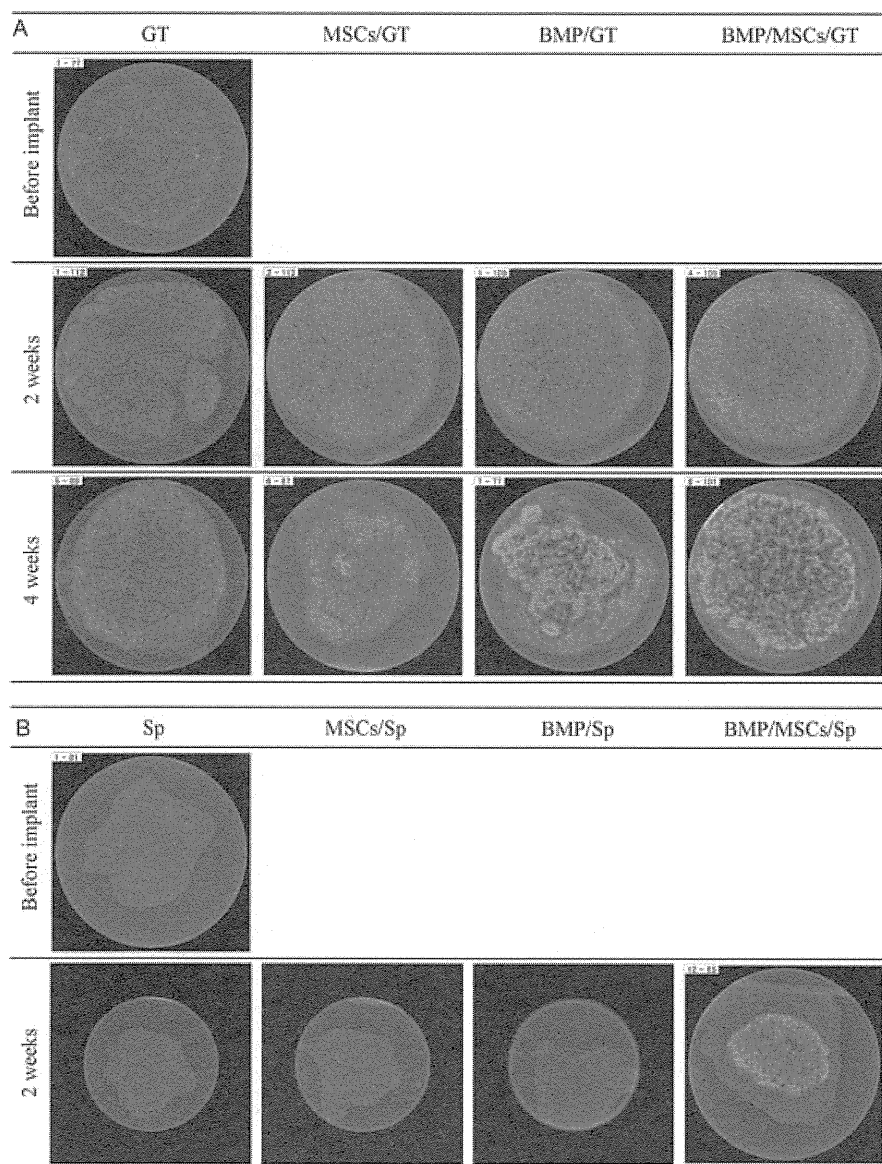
Typical micro-computed tomography (μ CT) images of the implants using gelatin- β -TCP (GT) and gelatin (Sp) sponges. Images of various implants using GT (A) and Sp (B) materials after *in vivo* implantation. The MSC-GT, BMP-GT and BMP-MSC-GT implants show high-intensity areas (white) as compared to the image of the GT-alone implant 4 weeks after implantation
